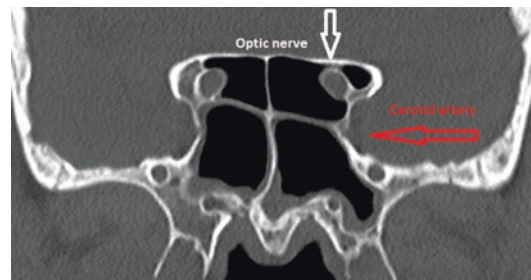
CT scan coronal section showing the optic nerve (dehiscent) within the sphenoid sinus (white arrow), carotid artery bulging inside the sphenoid sinus (red arrow)
